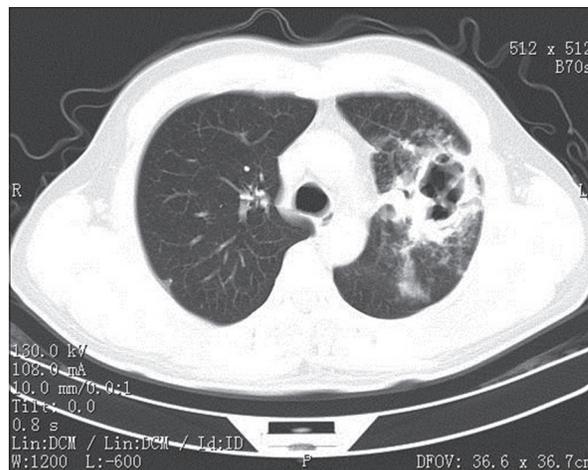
CT scan of the chest showing multiple cavitory lesions in the left lung
